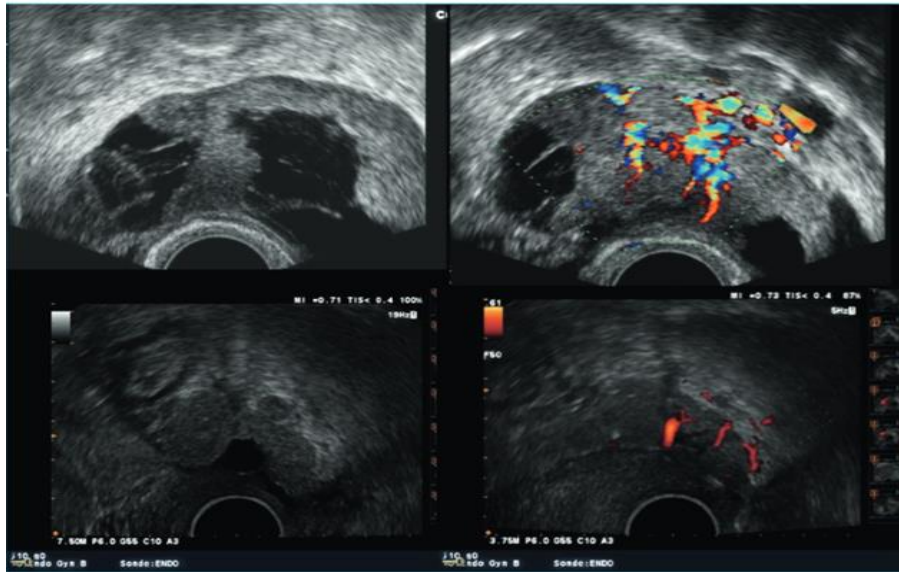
Typical Appearance of Ovarian Cancer on Endovaginal Ultrasound with Doppler.
